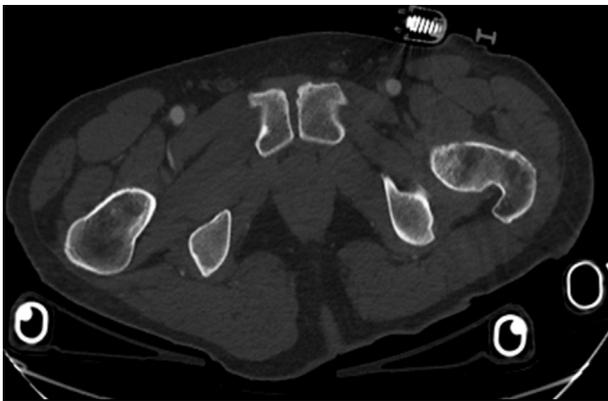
Axial CT of the pelvis in Grade I anteroposterior compression injury: original trauma CT demonstrating reduction of pubic diastasis in pelvic binder.
